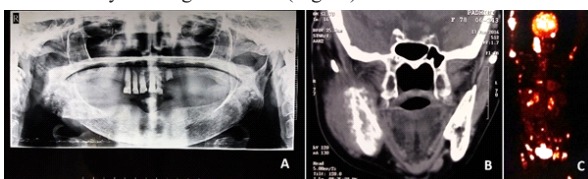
A-dental orthopantomogram showing osteolytic destructive lesion at the right mandibular posterior region; B -CT Coronal view-lytic destructive lesion with specks of bone formation and soft tissue mass, C -PET CT showing extensive and multiple metastatic lesions.
